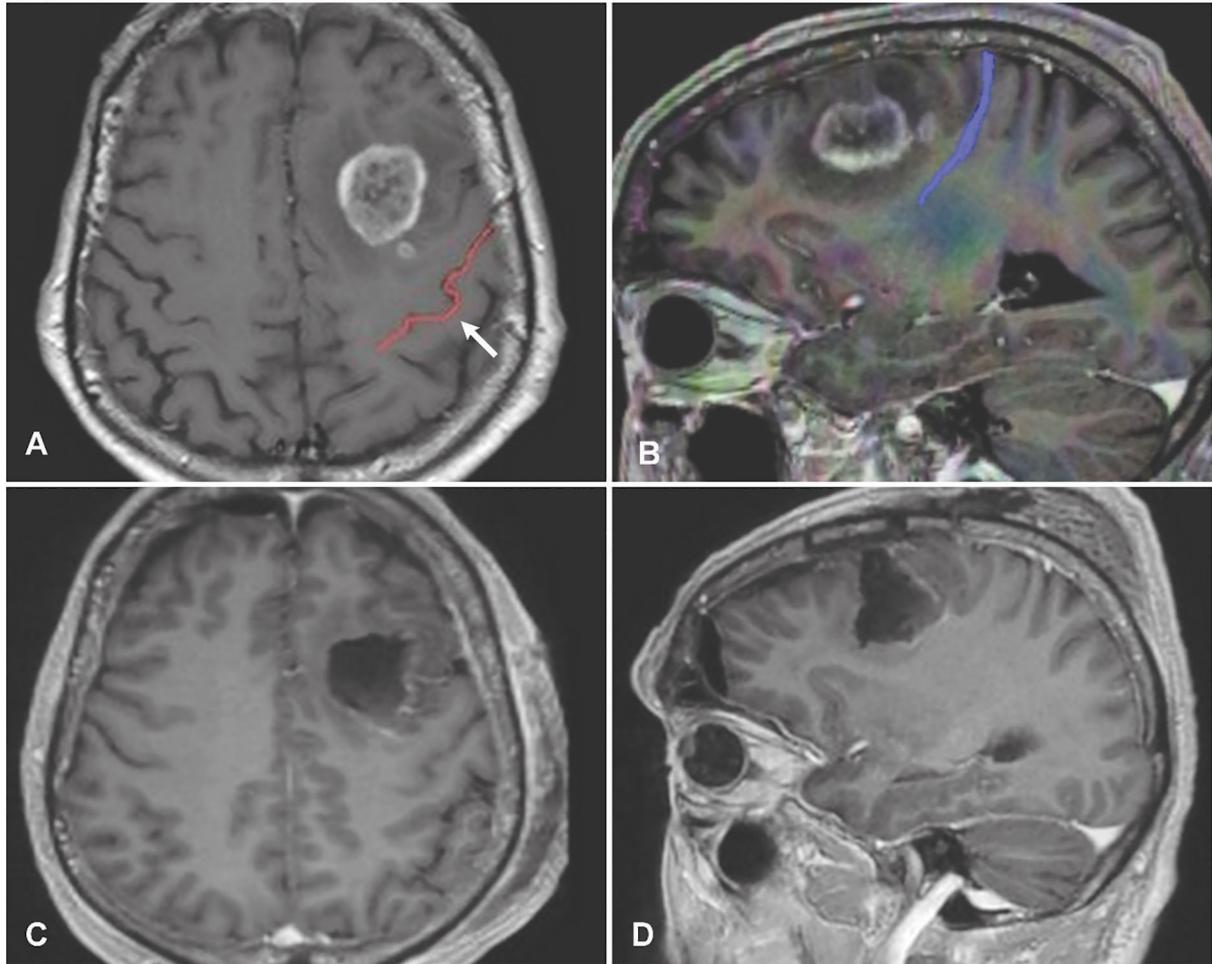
Preoperative contrast-enhanced MRI (A) and tractography (B) of a patient with a glioblastoma in the left precentral area. The arrow indicates the central sulcus. Tractography (B) shows the corticospinal tract less than 10 mm away from the tumor. Postoperative MRI (C, D) reveals gross total resection (C, D). No new postoperative motor deficit was noted.
